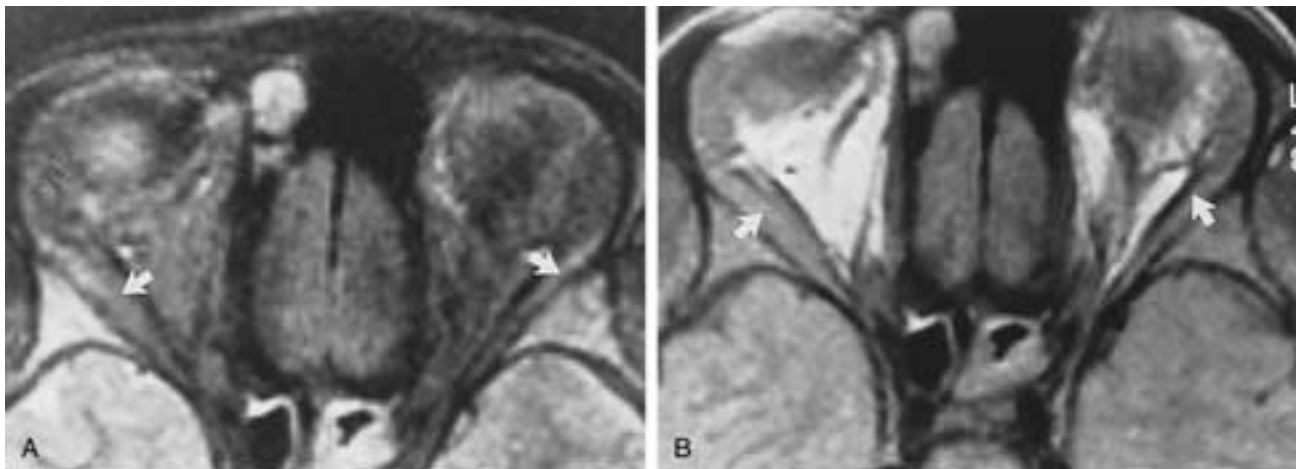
A, Axial PW scan. B, Axial T2-weighted MR imaging scan. Leukemic infiltration. Scans show bilateral subperiosteal leukemic infiltration (*arrows*).
